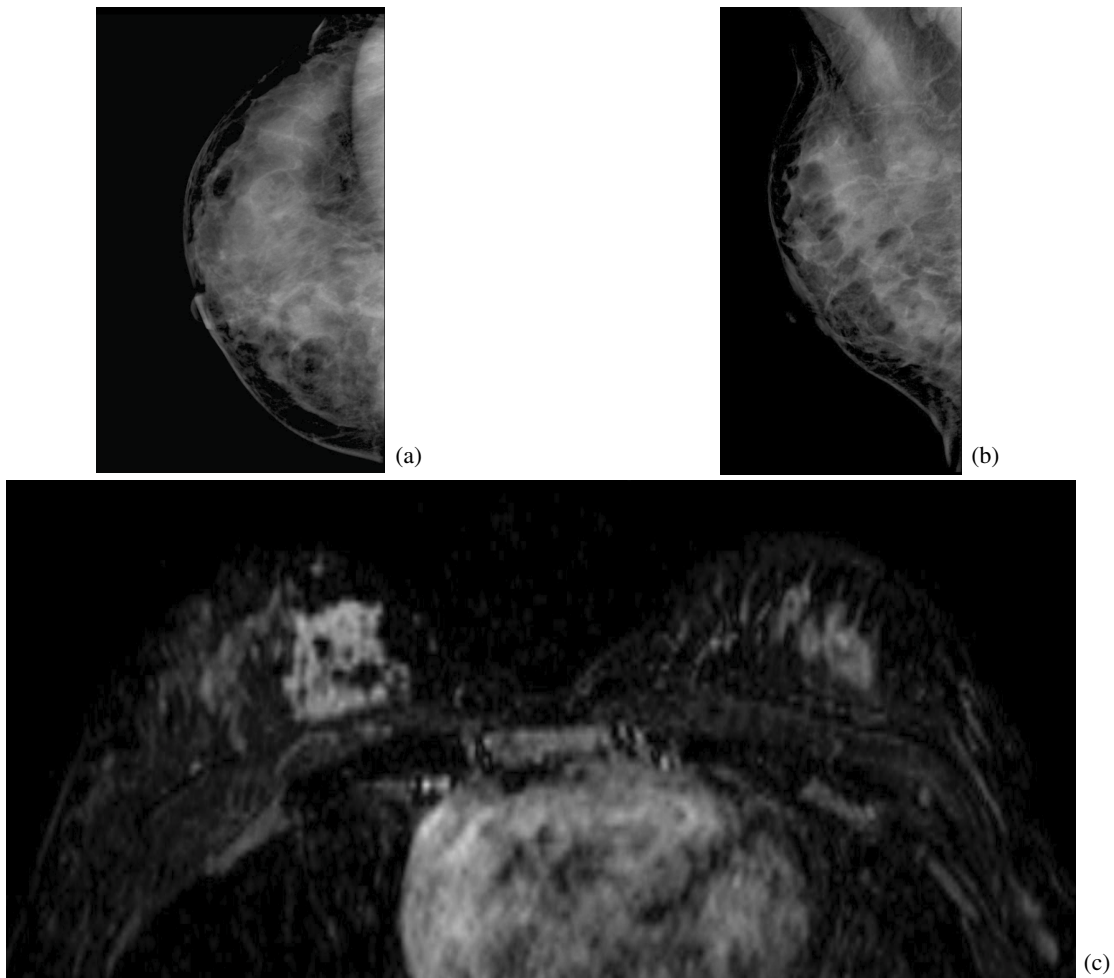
(a), (b) The mammography of a 32-year-old woman obtained during annual screening because of a proven BRCA₂ gene carrier. Very dense glandular tissue was seen on mammography. (c) The MRI from the same day. In the medial part of the right breast an irregular strong enhancing area was seen. Pathology showed an invasive duct carcinoma.
